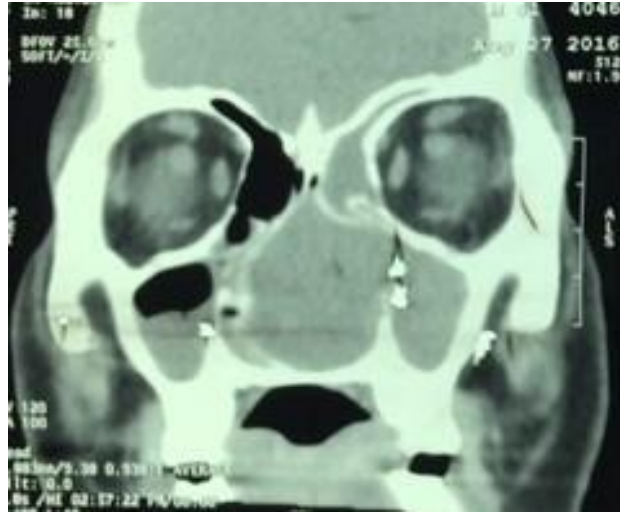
Coronal view of CT Scan PNS showing a well defined homogenous mass involving nasal cavity, maxillary, and ethmoid sinus.
